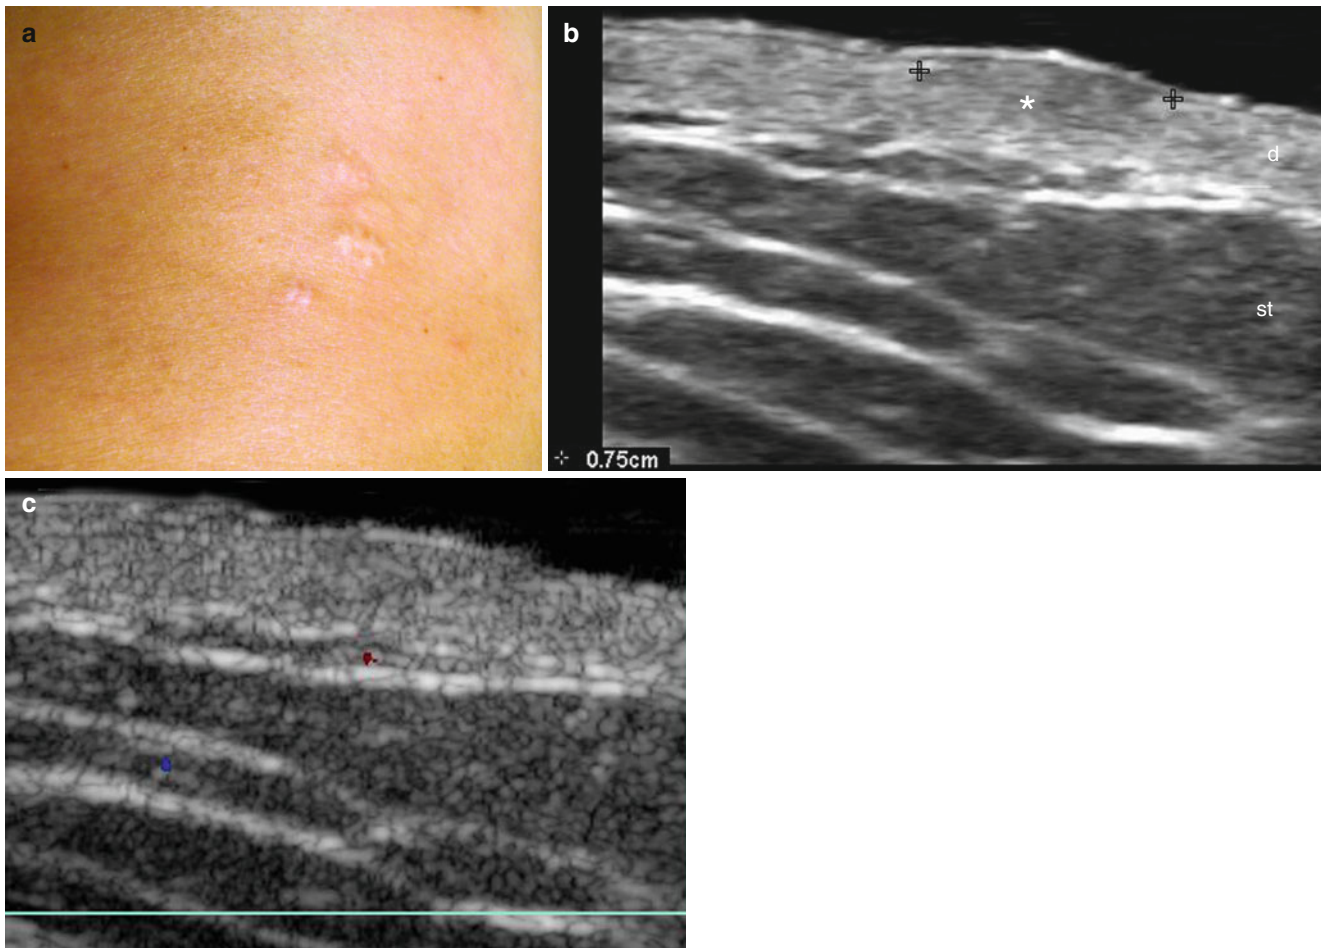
(a–c) Cutaneous lymphoma (mycosis fungoides). (a) Clinical image shows hypopigmented lumps in the left side of the anterior aspect of the thoracic region. (b) Grey scale ultrasound image (longitudinal view) demonstrates 0.75 cm ill-defined hypoechoic and heterogeneous structure (*) in the dermis. (c) Color Doppler ultrasound image (longitudinal view) demonstrates no signs of hypervascularity in the lesional region
